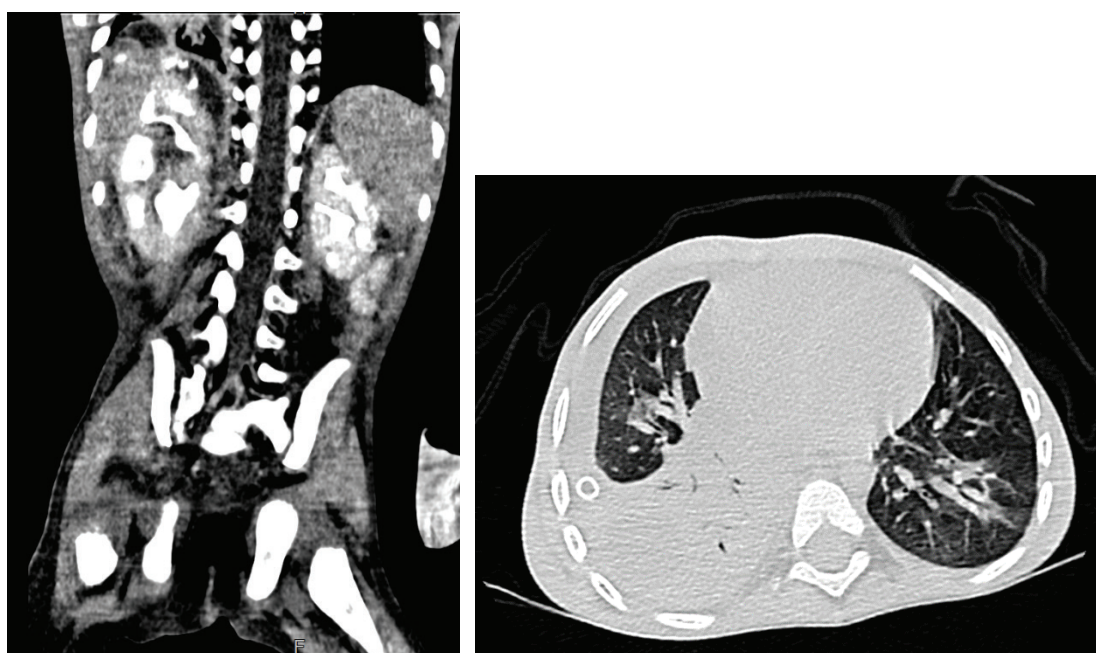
CT urography and pulmonary CT on the sixth postoperative day
